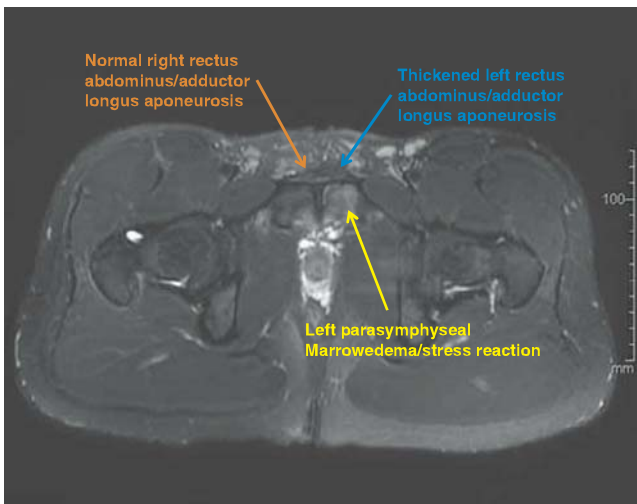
MRI that shows thickening in the distal rectus at the pubis on the left side (*arrow*). The right side is normal.
